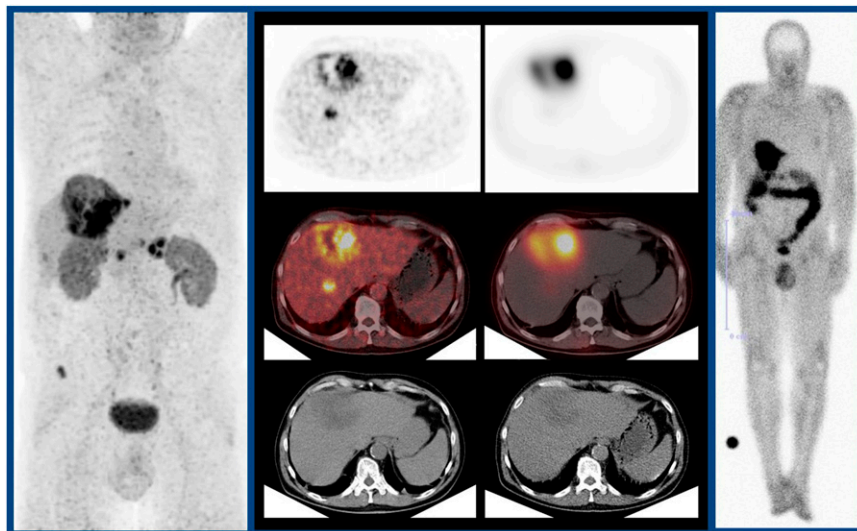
Peptide-targeted radionuclide therapy with ^{177}Lu -FAP-2286 in adenocarcinomas. Example imaging in a patient with pancreatic adenocarcinoma with hepatic, lymph node, and bone metastases. Left full-body and column of 3: ^{68}Ga -FAP-2286 PET/CT. Right column: ^{177}Lu -FAP-2286 SPECT/CT. Right full body: ^{177}Lu -FAP-2286 scintigraphy.
